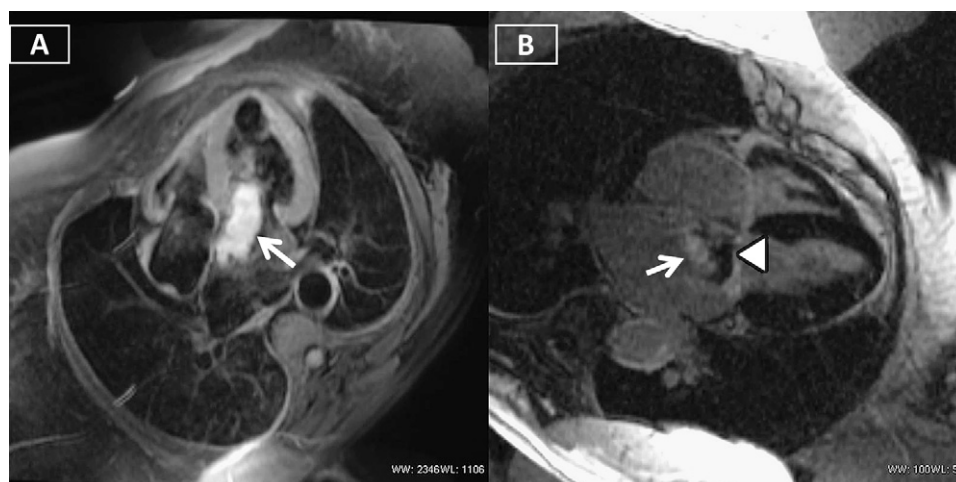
Cardiac magnetic resonance imaging. (A) Double inversion recovery fast spin-echo image with fat saturation in the four-chamber view shows high signal mass (*arrow*) in left atrium extending across the mitral valve. (B) Contrast-enhanced inversion recovery gradient-echo magnetic resonance image in the four-chamber view shows enhancement of tumor (*arrow*).
